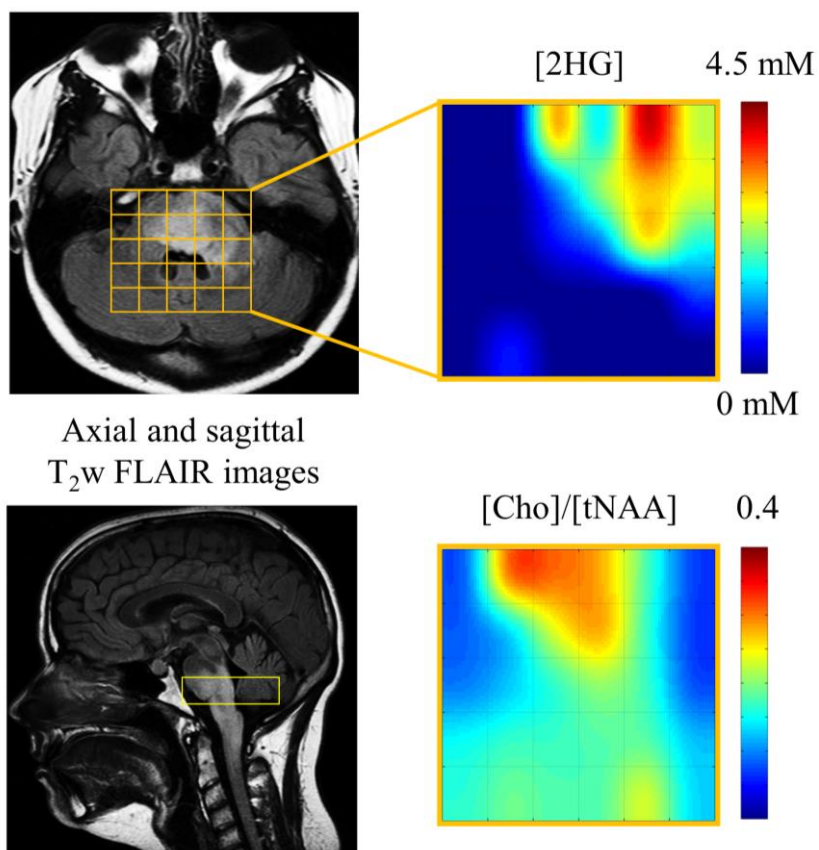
Subject with hyper-intensity in brain stem on a T₂w-FLAIR image.
